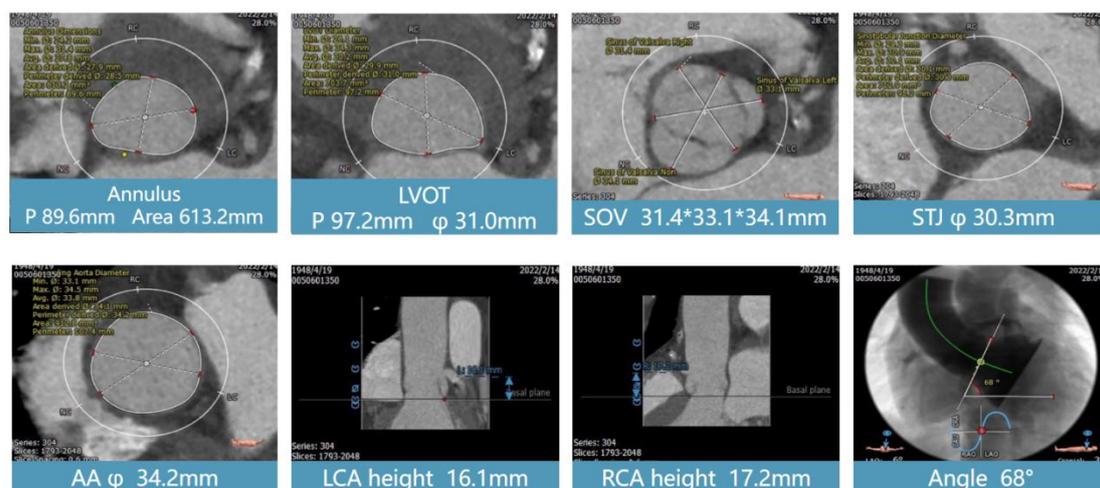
A preoperative CT evaluation showed the dilated annulus (area 613.2 mm<sup>2</sup>, perimeter 89.6mm) and normal ascending aorta dimensions.
